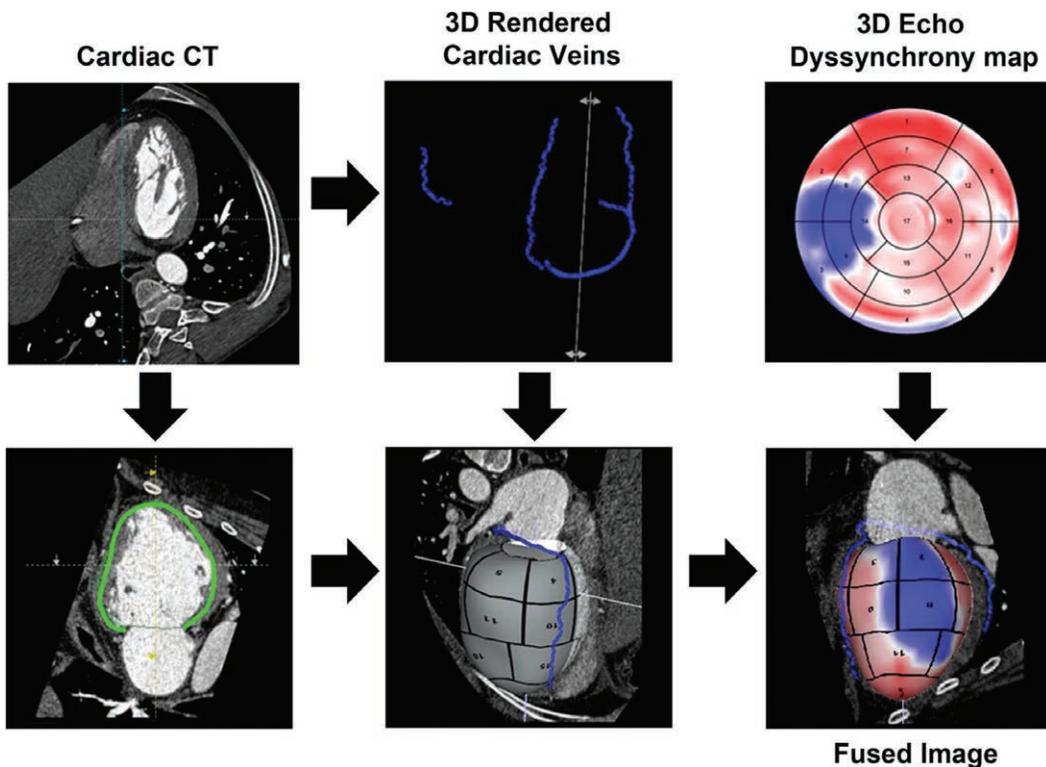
Fusion of cardiac computed tomography, imaging of cardiac veins, and echocardiographic imaging with a dyssynchrony map (courtesy of Dr. Roberto Lang). This could optimize the localization of biventricular pacing leads in patients with heart failure and ventricular dyssynchrony.
